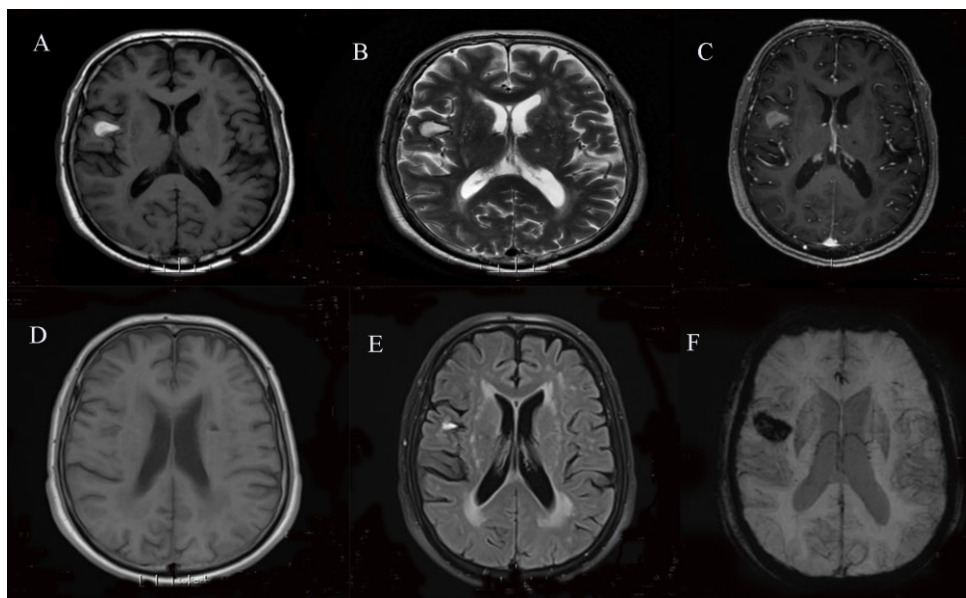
Axial T1-weighted, T2-weighted and T1-enhanced sequences (A-C) of brain MRI images indicate a lesion in the right frontal lobe exhibiting hyperintensity without contrast enhancement, consistent with cerebral hemorrhage. Twelve days later, a follow-up brain MRI examination was performed. Axial T1-weighted imaging (D) revealed a reduction in lesion volume with a corresponding decrease in signal intensity to hypointensity. Axial fluid-attenuated inversion recovery (FLAIR) imaging (E) demonstrated a hyperintense signal, while SWI (F) displayed a hypointense signal. These features are indicative of post-hemorrhagic changes and correlate with partial resorption of the hematoma.
